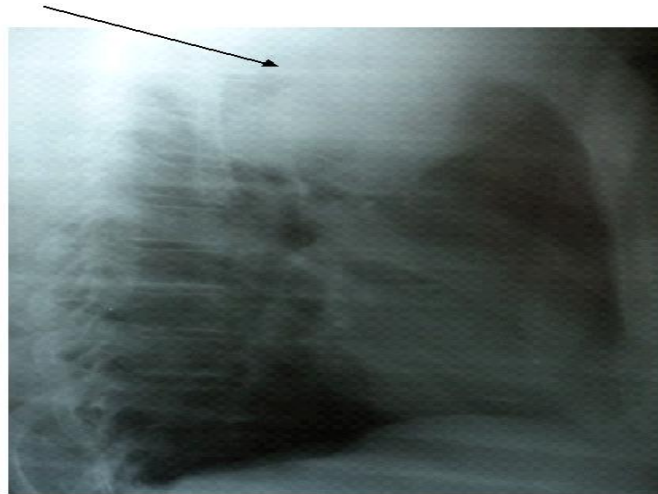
Chest radiograph (right lateral view) shows the mass is located in superior aspect of middle mediastinum abutting the aortic arch. With these features and location of the mass it appears to be a lymphoma
